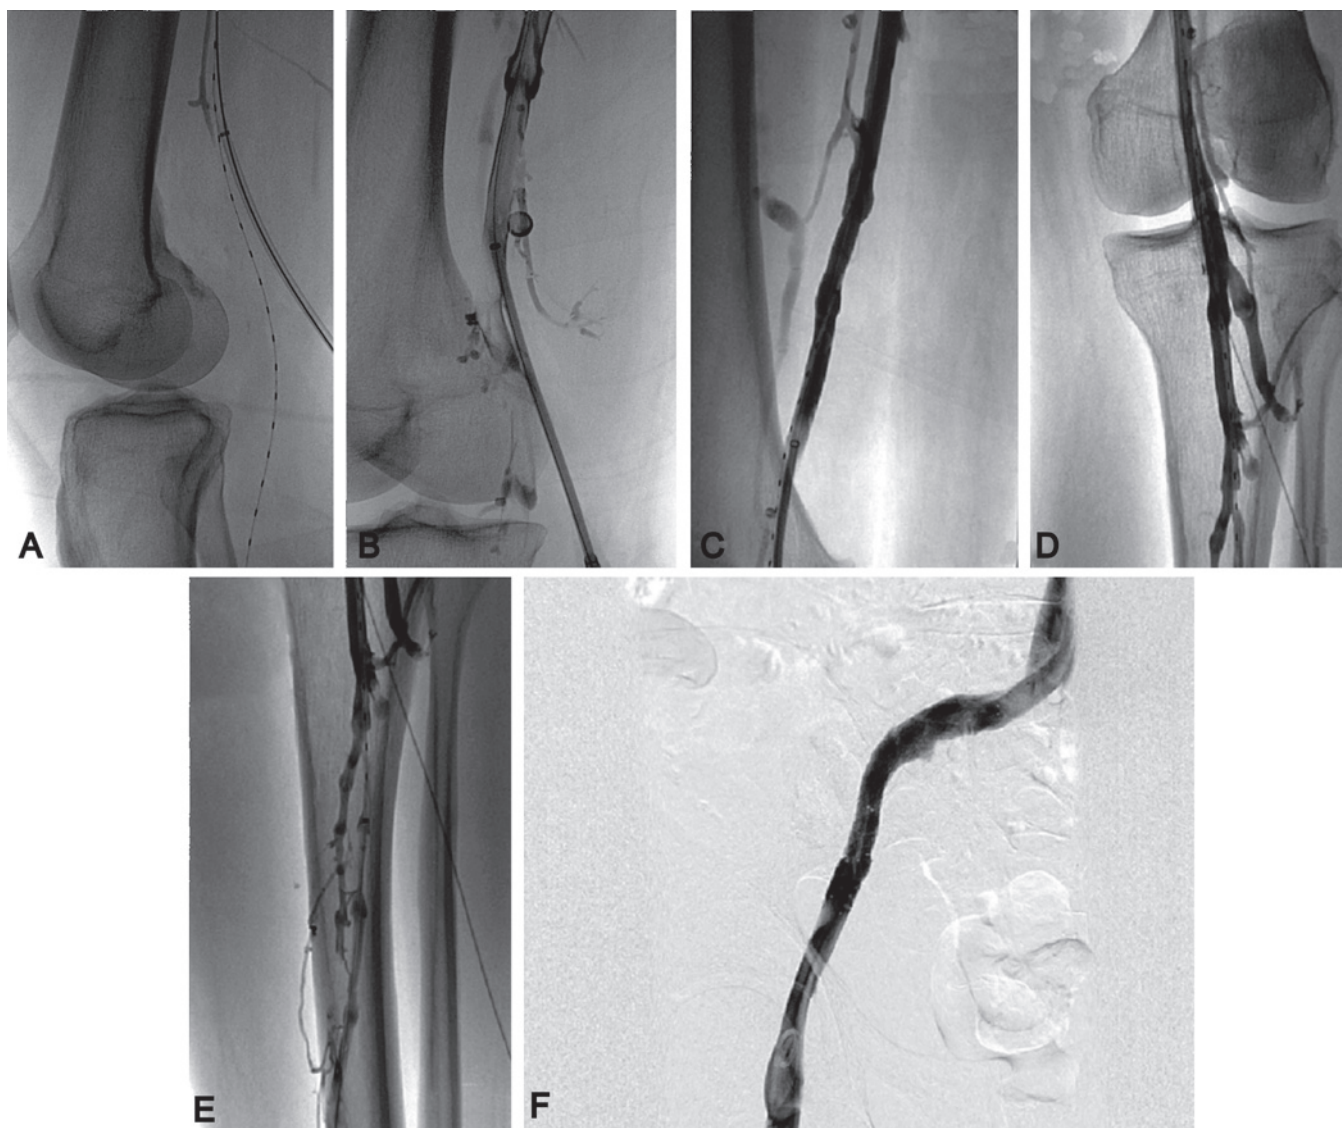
A. The EKOS LysUS® System (EKOS Corp, Bothell, WA) is an ultrasonic infusion system designed for controlled and selective infusion of thrombolytics into the thrombosed veins. Ultrasound waves accelerate thrombolysis, reducing treatment time. The catheter was advanced proximally from an ultrasound-guided posterior tibial vein puncture. B. Phlebogram showing popliteal vein thrombus. C. Post-ultrasound lysis, dissolution of thrombus in the distal femoral vein, D. popliteal vein, and E. posterior tibial vein. F. Angioplasty and stenting were performed on the left iliac vein, establishing normal venous drainage into the inferior vena cava.
